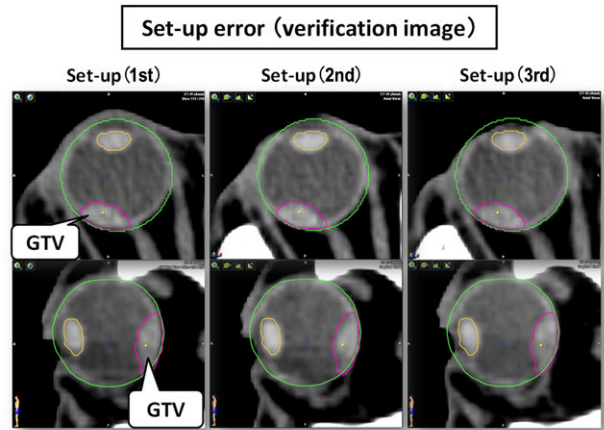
Repeated computed tomography images obtained in the transverse (top) and sagittal views (bottom) verified the reproducibility of the position of the eyes using the F–M device in Patient #1. Image registration was performed not only on the bony structure with the ExacTrac system, but also on the eyeball with the optic axis guide.
